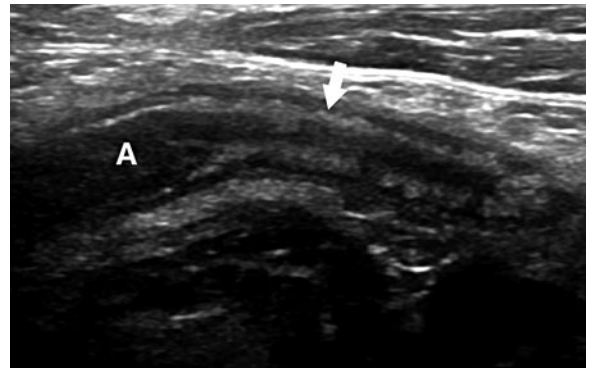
Resolving appendicitis on sonography. Zero Gray-scale sonogram through long axis of appendix demonstrates fluid distension of proximal appendix (“A”), and submucosal and mural thickening of distal appendix (*white arrow*). Findings were consistent with early acute appendicitis; however, patient’s symptoms resolved at time of scanning and patient made uneventful recovery without surgery
